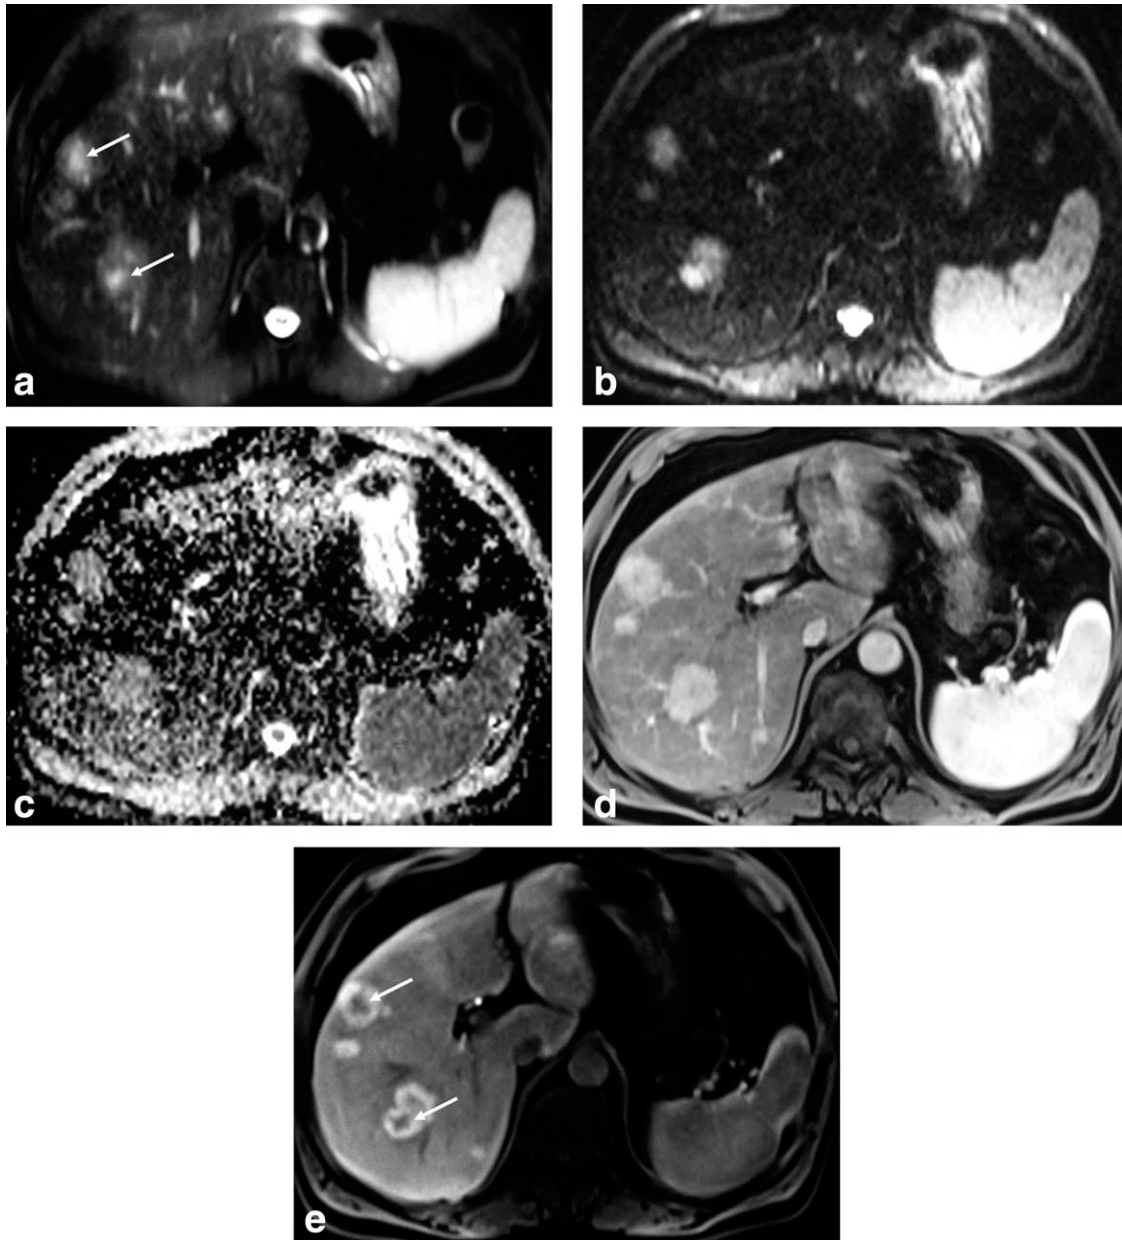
Multiple FNHs in a 63-year-old man. a: Transverse fat saturated T2-weighted image. b: Transverse DWIs obtained with a b-value of 50 s/mm^2 , and (c) ADC map (d) dynamic contrast-enhanced MR images with Gd-EOB-DTPA in the arterial phase (e) and in the hepatobiliary phase. On fat-saturated T2-weighted images, three FNHs with moderately high signal are shown in segments VII–VIII. The margins of the three lesions are irregular and the central parts of the two larger lesions (arrows) show markedly high signal intensity on the T2-weighted images. The two FNHs were misjudged as malignant lesions (a score of 3) by both readers because they mimicked metastatic lesions with central necrosis. The three FNHs also display moderately high signal intensity at DWI obtained with a b-value of 50 s/mm^2 . On the corresponding ADC map, the three FNHs demonstrate clear hyperintensity with relatively high ADCs ($1.48 \times 10^{-3} \text{ mm}^2/\text{s}$) compared to surrounding liver parenchyma, and the lesions were correctly judged as benign (a score of 1) by both readers. The three FNHs demonstrate intense arterial enhancement and remain hyperintense in the hepatobiliary phase, which are typical features of FNH. The central hypointense areas (arrows) within the masses are shown on the hepatobiliary phase image, which corresponds to central vascular scars.
